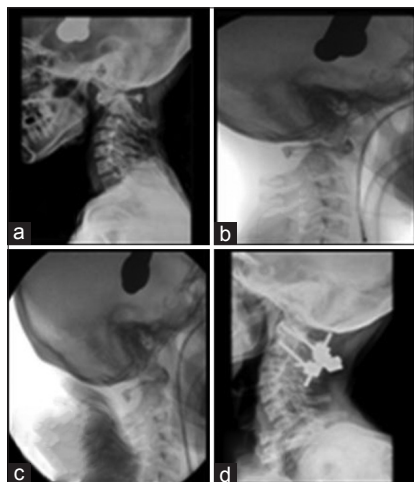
Case 2 AAD with odontoid fracture: (a) preoperative X-ray showing odontoid fracture with AAD, (b) intraoperative X-ray after positioning under general anesthesia before thumb maneuver showing AAD, (c) intraoperative X-ray after positioning under general anesthesia after thumb maneuver showing reduction of AAD, (d) postoperative X-ray showing implant *in situ* with reduction of AAD
